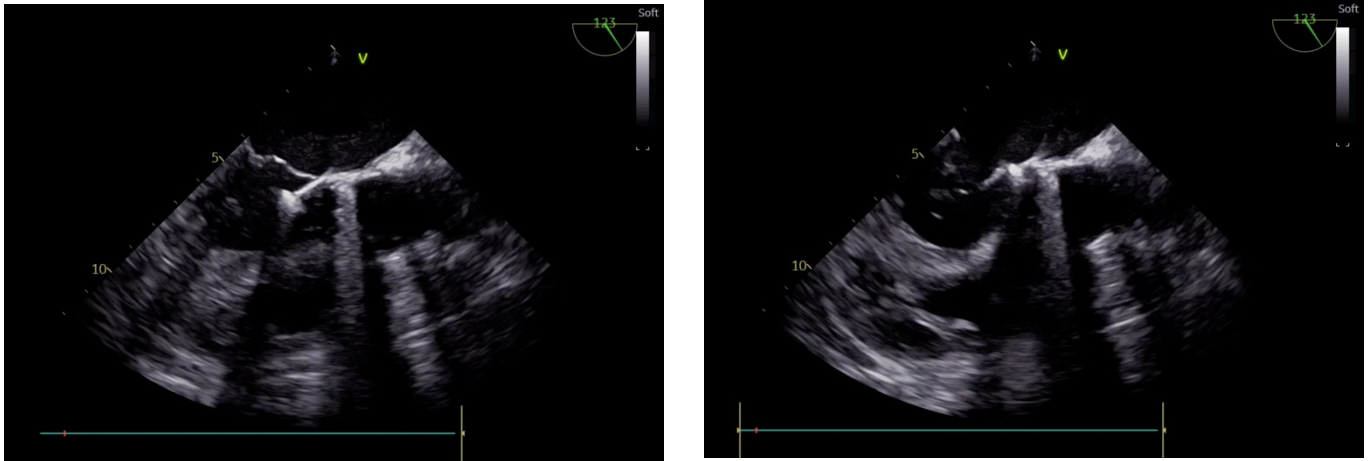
Transesophageal echocardiography images of (a) The Agilis catheter crossing anterior mitral leaflet in the left atrium (b) 6 mm Lifetech symmetrical Musd occluder placement into the perforation on the mitral anterior leaflet.
